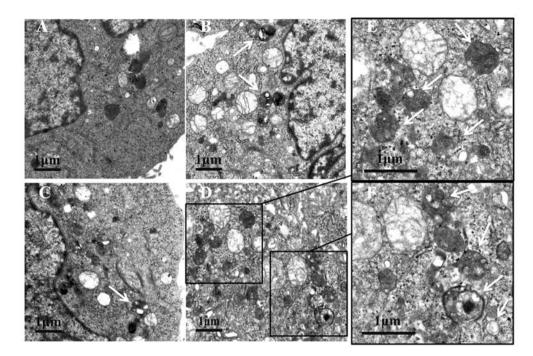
The representative electron graphs of the cellular ultrastructure of X-rays-treated cells. Hepa1-6 cells were transfected with AdNull (A,B) or AdHBx (C,D). After 24 h of incubation, cells were treated with or without X-rays. (A and C) Cells treated without X-rays; (B and D) cells irradiated with X-rays at 50 Gy (E and F) the same cells as (D) with different magnifications. Arrows point to autophagosomes or autolysosomes.
